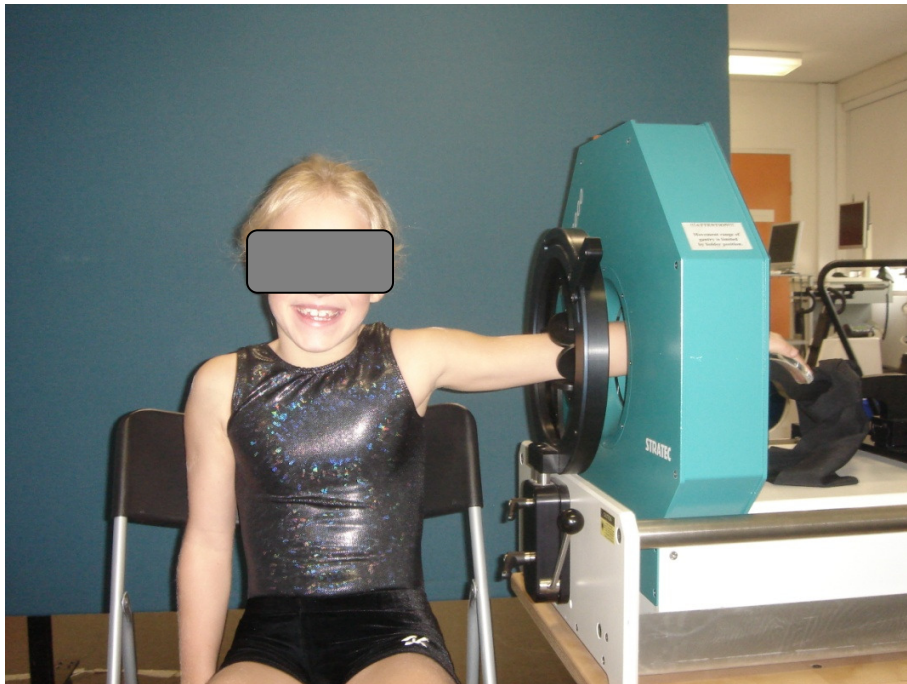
A peripheral quantitative computed tomography scan of the non-dominant forearm
